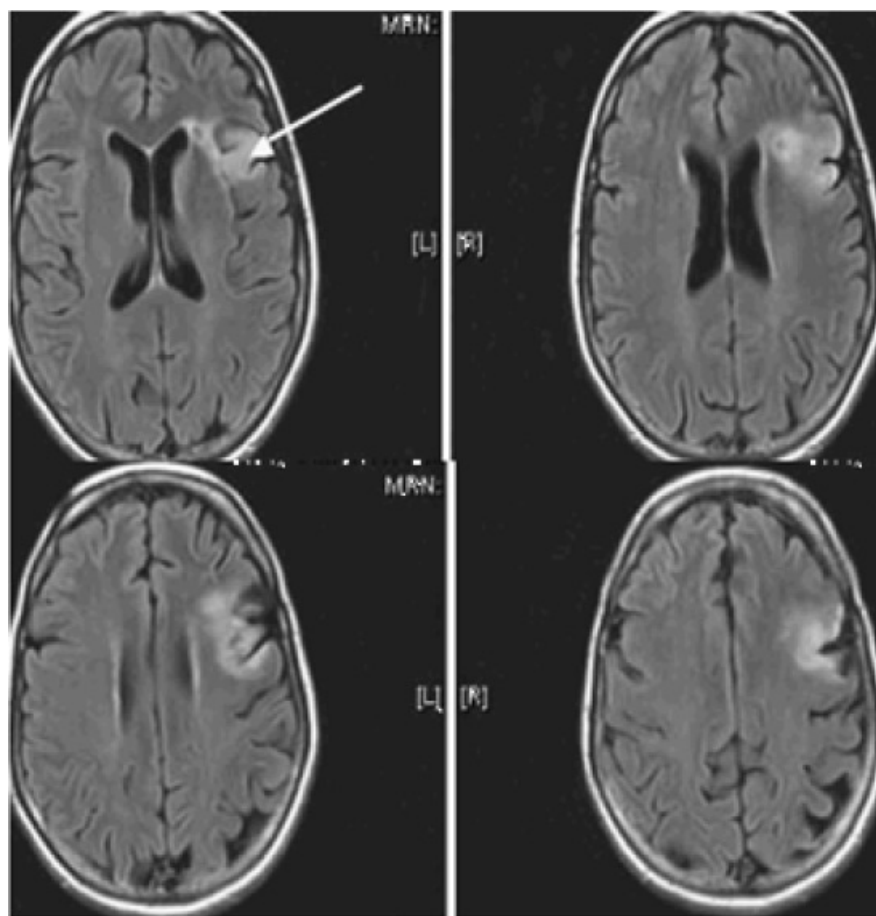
T1 axial MRI at six weeks after infarction; note edge of lesion in superior operculum (arrow) reaching to white matter above anterior limb of internal capsule, but center of lesion is in middle frontal gyrus.
